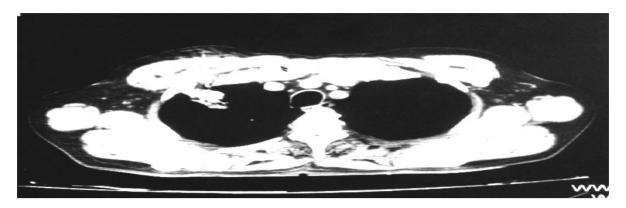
Needle in mass lesion during CT guided FNAC
